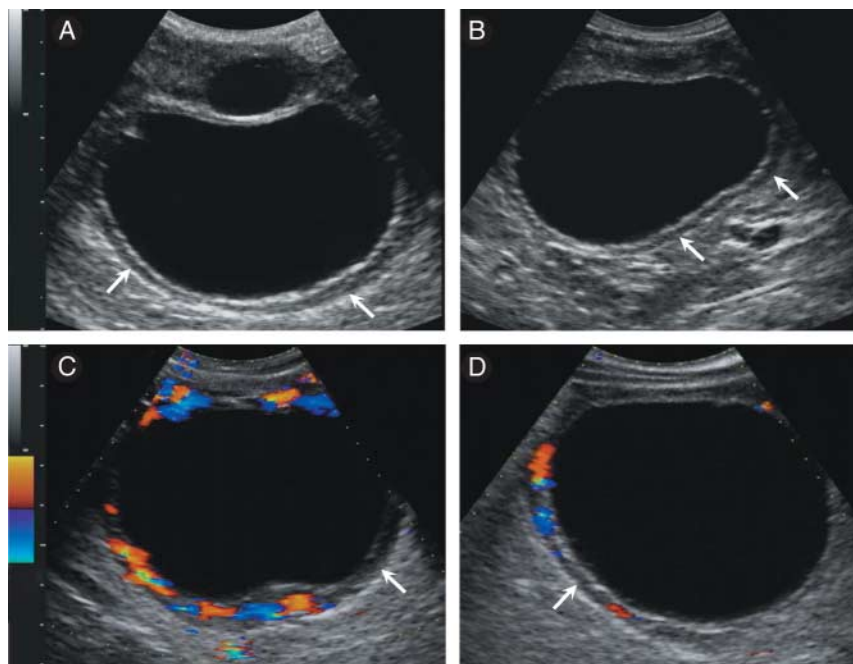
Selected B-mode (A and B) and colour-Doppler (C and D) ultrasonograms of pre-ovulatory follicles of four control mares. (A and B) Ultrasonograms at 2 days after the largest follicle reached ≥ 35 mm (treatment time) and 1 day before ovulation. (C) Ultrasonogram at 4 days after the largest follicle reached ≥ 35 mm and 2 days before ovulation. (D) Ultrasonogram at 4 days after the largest follicle reached ≥ 35 mm and 3 h before ovulation. Images in panels A and D were magnified to improve visibility of the anechoic band (arrows) and colour-Doppler signals located within or extending beyond the width of the anechoic band. Distance between graduation marks (left) is 1 cm.
